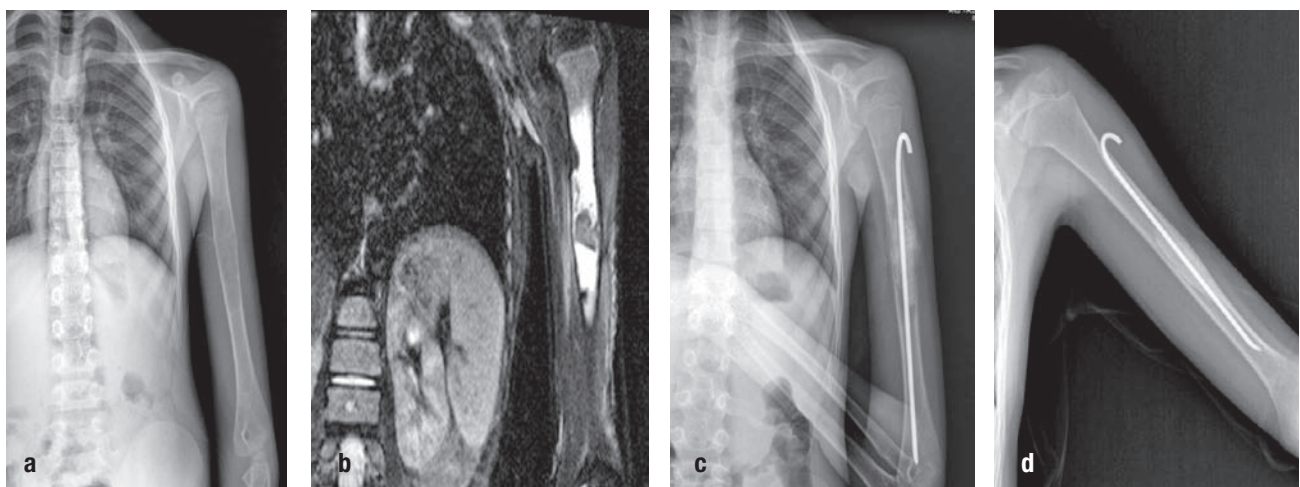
8-year-old male patient. He was operated for BCC located in the left humeral diaphysis. Cyst decompression, curettage and allograft and FIN were performed. After 60 months of follow-up, it is seen that the cystic cavity is filled with new bone and the bone is fused. Grade 1 improvement was detected according to Capanna criteria. a – preoperative X-ray; b – preoperative MRI section; c – postoperative 1st week control X-ray; d – final control X-ray.
